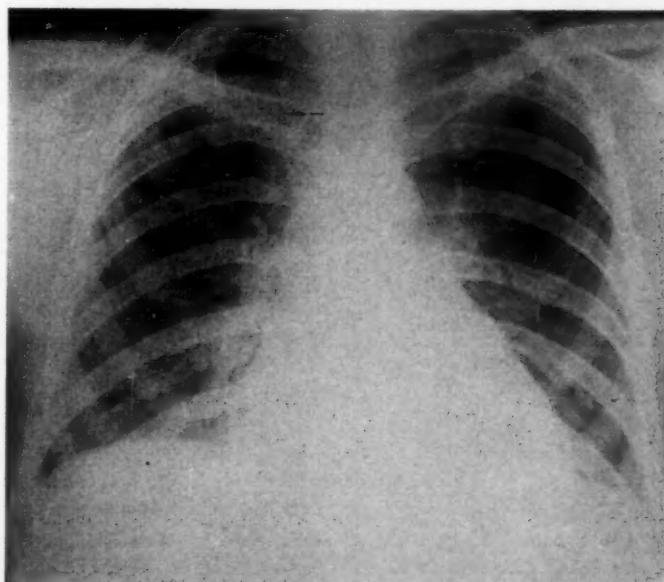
Roentgenogram of the chest prior to death, showing marked cardiac enlargement and pulmonary congestion.
